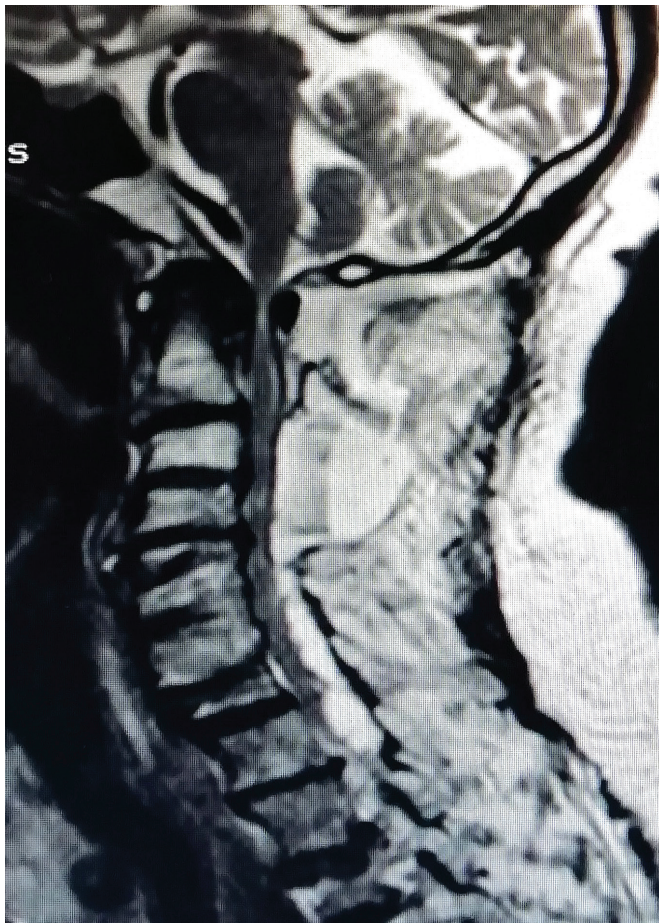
Postoperative sagittal T2-weighted magnetic resonance imaging show the hemorrhage
